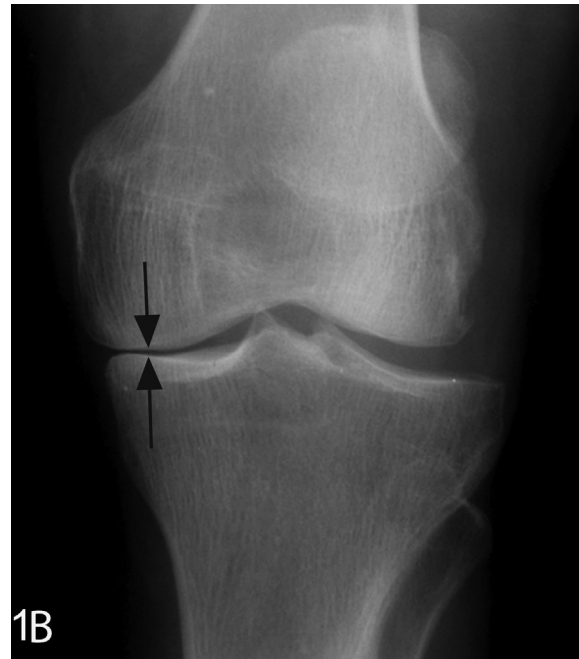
6 months follow-up radiograph depicts definite medial joint space narrowing (JSN; arrows) with persistent absence of osteophytes medially consistent with RPOA.
